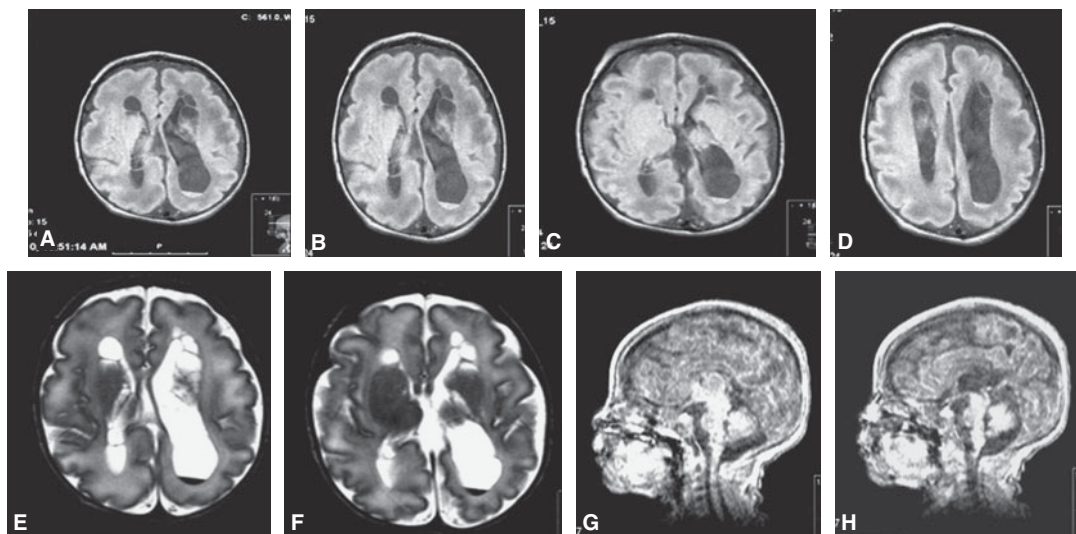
MRI of intraventricular hemorrhage grade II of the newborn (same case as in Figures 10-20, 10-21, 10-22, and 10-26). Showing areas of bleeding as well as some intracranial adhesions consistent with the fetal intracranial hemorrhage. (A–F) Axial sections. (G, H) Sagittal sections.
